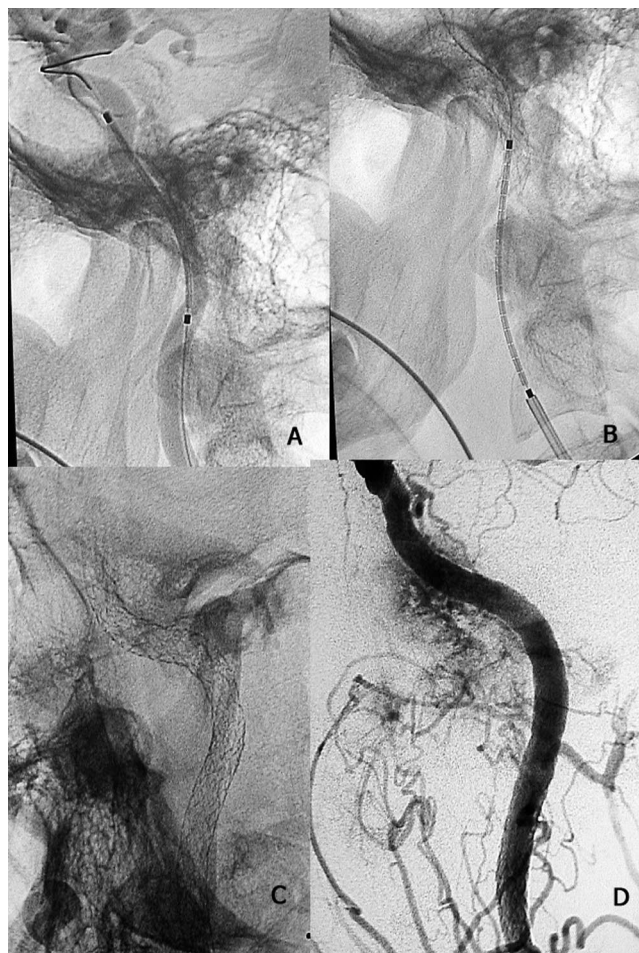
(A and B) Insertion of the stents in the petrous and cervical portions of the internal carotid artery (ICA). (C) Digital x-ray in oblique projection showing the stents fully deployed in the petrous and cervical segments of the ICA. (D) Digital subtraction angiography of the ICA after stenting showing resolution of the stenosis.
